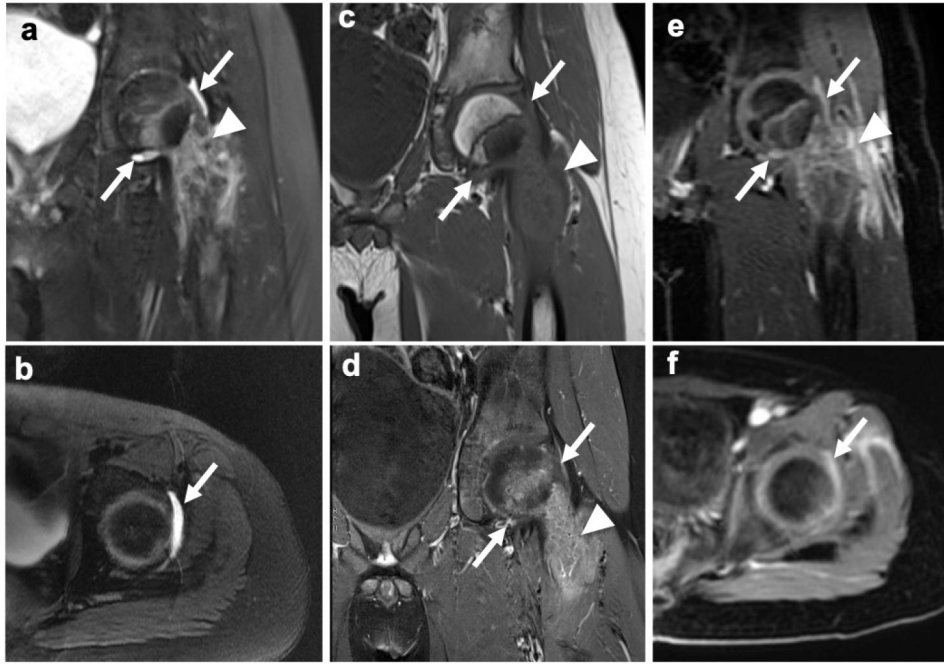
Subtle ferumoxytol leak into a joint effusion of 9-year old male patient with an osteosarcoma in the proximal left femur and unclear infiltration status based on unenhanced and gadolinium-enhanced MR imaging. a,b Coronal and axial T2-weighted fast spin echo (FSE) images show an inhomogeneous tumor in the proximal left femur (arrowhead) and a subtle joint effusion (arrows). c Corresponding pre-contrast coronal T1-weighted FSE image and d post-gadolinium T1-weighted FSE image with fat saturation show no definite signs of joint infiltration and no enhancement of the effusion (arrows). e,f However, on coronal and axial ferumoxytol-enhanced LAVA images at 24 hours a hyperintense signal of the joint effusion is demonstrated, suggesting ferumoxytol leakage.
